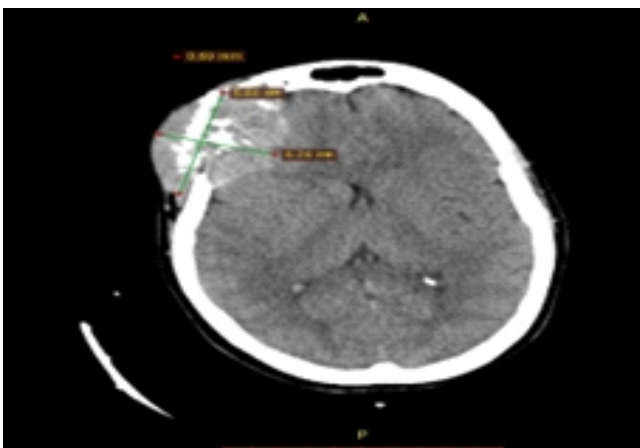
Axial (A) and 3DC (B) Contrast enhanced computed tomography of head showing large lytic area involving right frontal and parietal bones.
